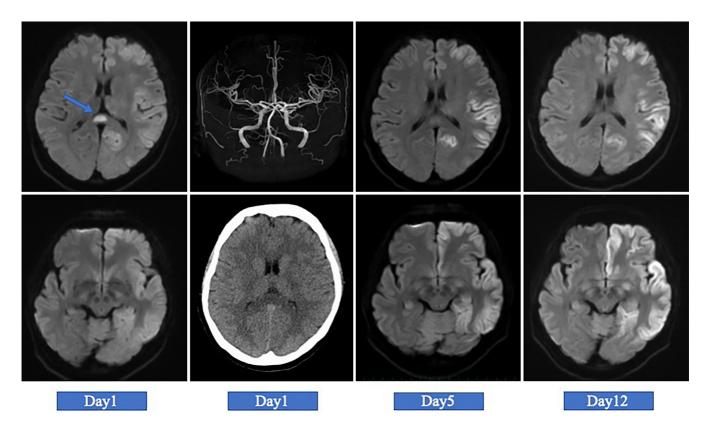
(A) Initial brain magnetic resonance imaging (MRI) findings on the first day of intensive care admission. Initial diffusion-weighted MRI revealed a hyperintense signal (blue arrow) in the splenium of the corpus callosum, considered to be consistent with a diagnosis of mild encephalitis/ encephalopathy with a reversible splenial lesion. Magnetic resonance angiography showed no abnormal findings or vascular occlusion, and head computed tomography (CT) showed no signs of bleed-ing. (B) Follow-up diffusion-weighted MRI showed the resolution of the hyperintense signal in the splenium of the corpus callosum. However, a hyperintense signal along the left cerebral cortex remained.
